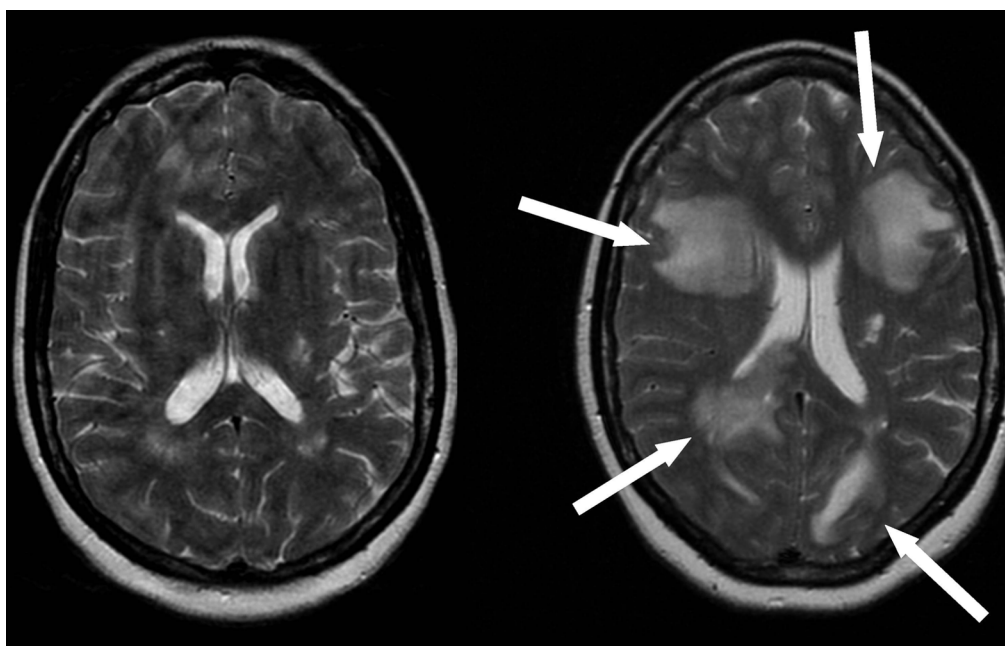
MRI (right panel) showing multiple non-enhancing white matter areas of demyelination (arrows) consistent with progressive multifocal leukoencephalopathy, grossly different from the previous MRI (left panel) showing T2 signal lesions in the white matter more consistent with lupus cerebritis.
